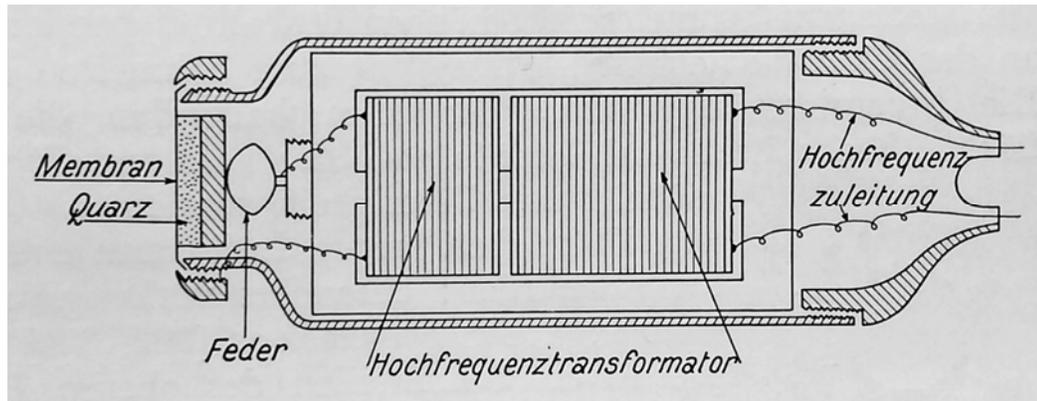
Ultrasound transducer for therapy. 800 kHz. Pohlmann 1939.
